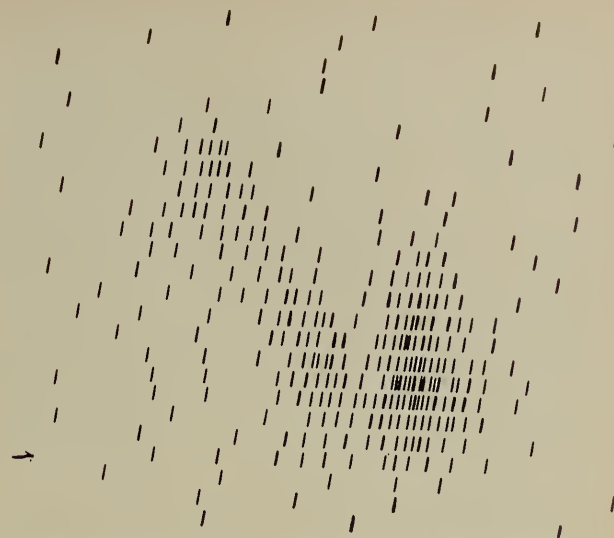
Thyroid scintigram showing an area of decreased I^{131} uptake in a solitary nodule of the right thyroid lobe.
